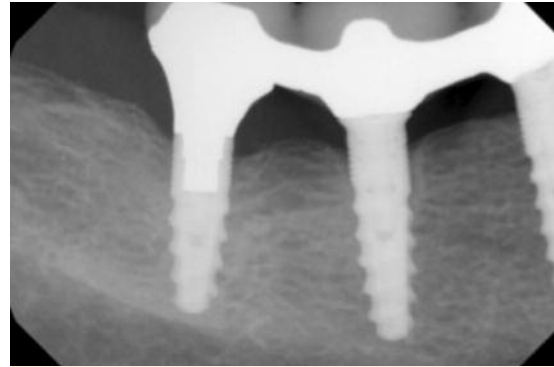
The X-ray image shows minor involvement of the hard tissue.
